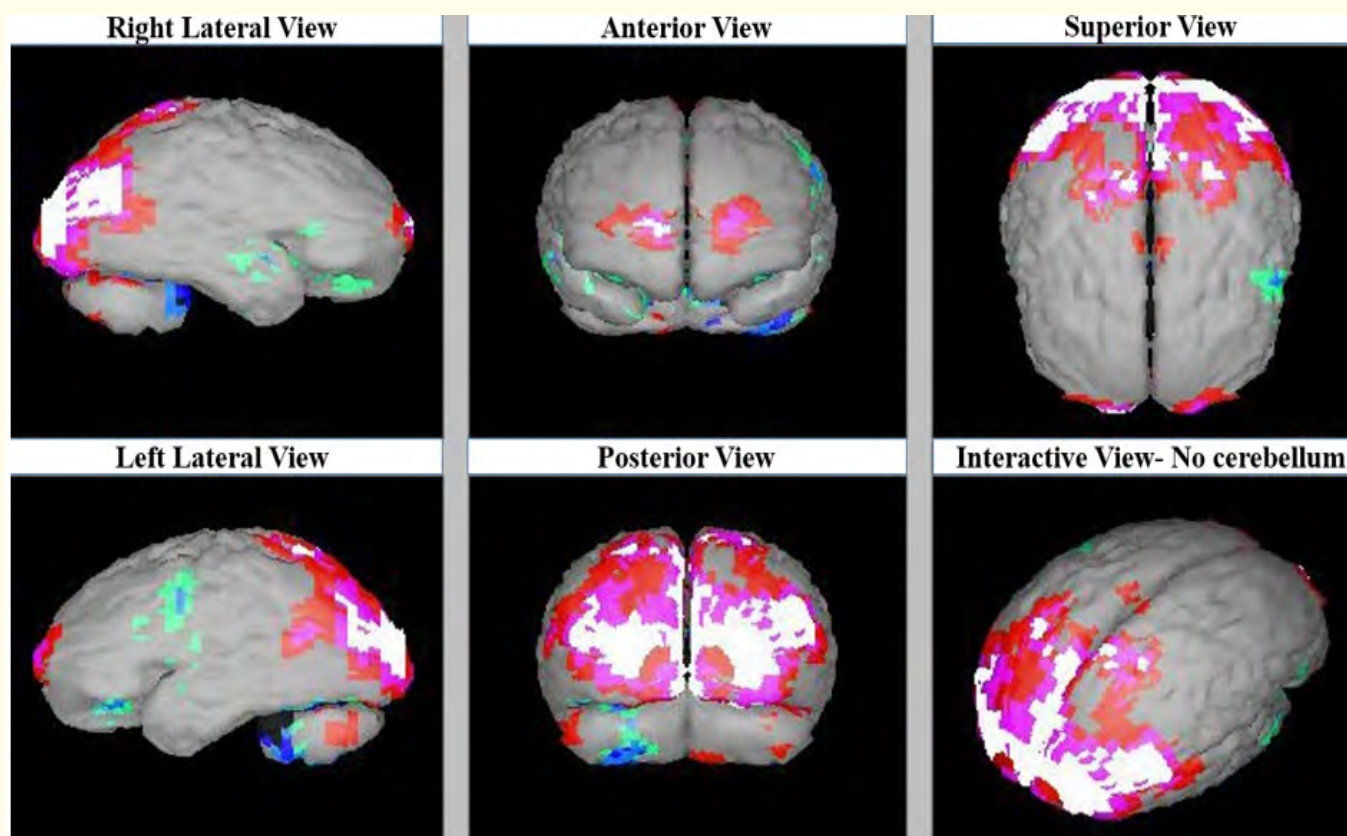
SPECT scan of ALS disease patient's after therapy showing improved perfusion.
